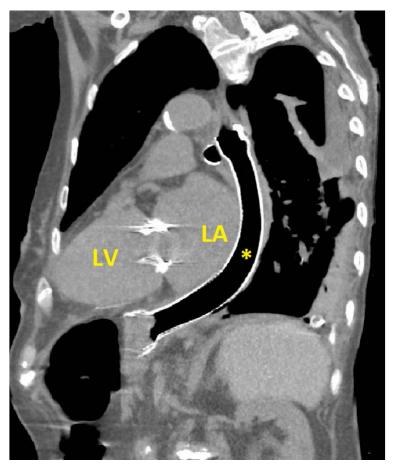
Final computed tomography evaluation of stent deployment in the oesophagus (asterisk) with no residual communication. LA: Left Atrium; LV: Left Ventricle.
